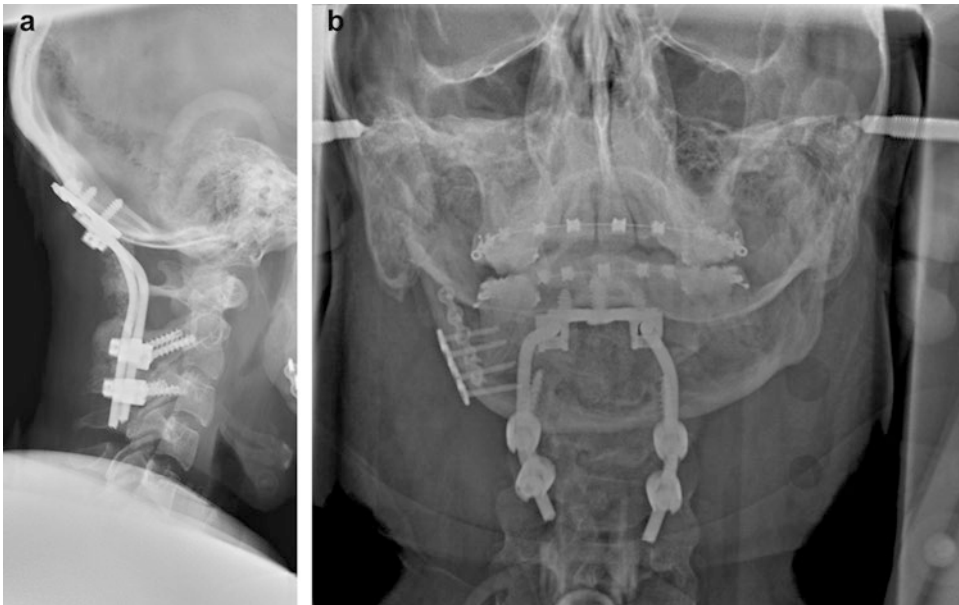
(a) Lateral cervical spine and (b) AP cervical spine radiographs of a patient with an occiput to C3 fusion with craniovertebral instrumentation
